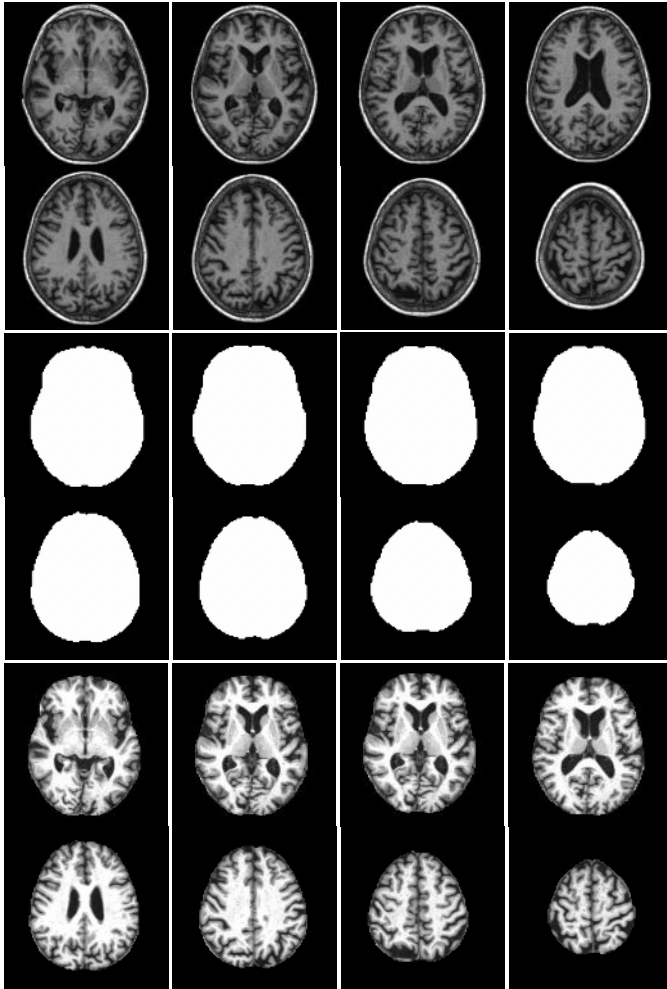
Skull stripped brain MR images of a patient for one full data sequence in transverse plane
